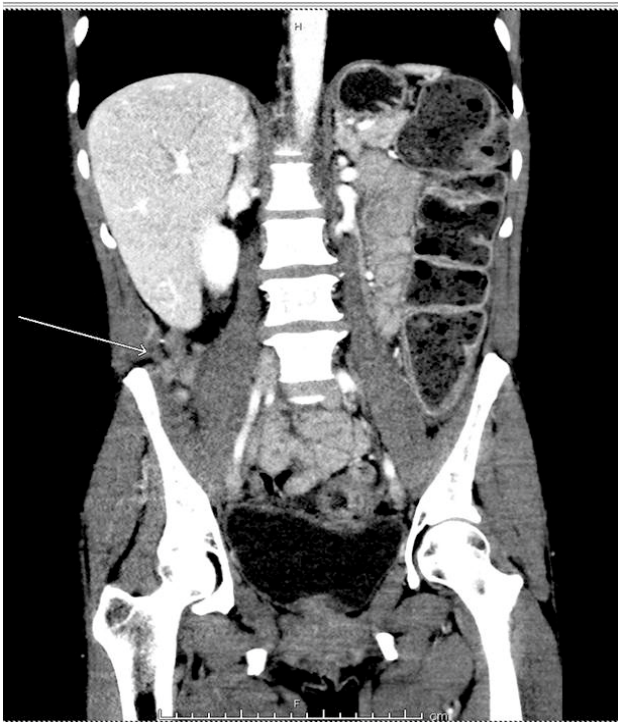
Abdominal computed tomography revealed findings consistent with peritoneal carcinomatosis more than two years from her original operation and after six cycles of carboplatin and four cycles of paclitaxel.
